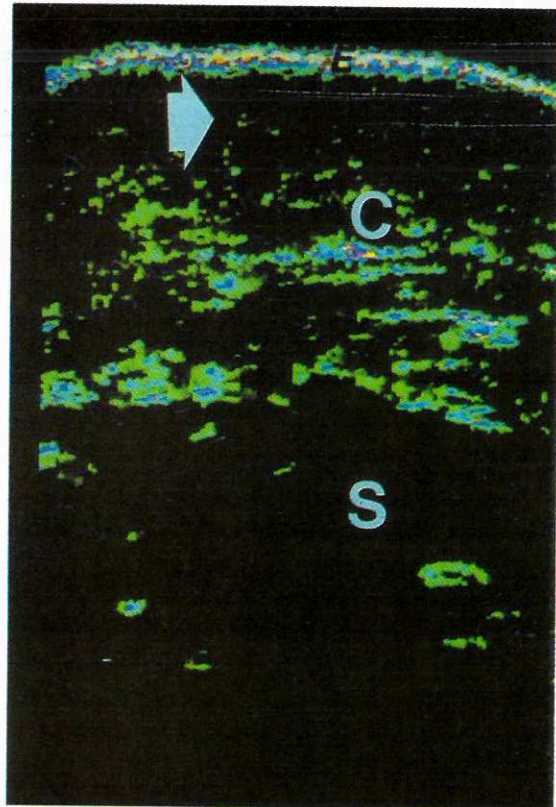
Ultrasound B-scan of diseased skin on the left lower leg (Case Study 3) (E: entry echo; C: corium; S: subcutaneous fatty tissue; white arrow: loosely structured subepithelial region).
